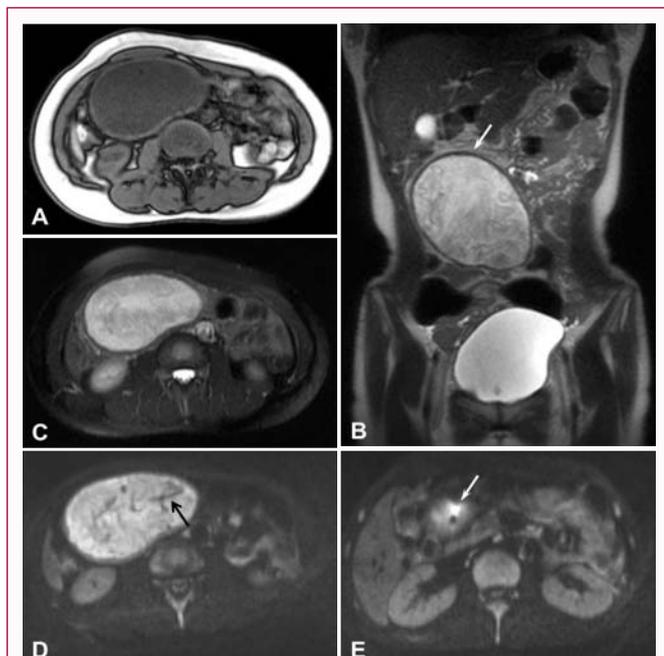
A 30-year-old woman with a mass in her abdomen 5 years after caesarean section. A-E: Unenhanced MRI scan showed a mass in her abdomen with complete capsule at the margin (white arrow), DWI showed swirling slightly lower signal shadow and strip lower signal band (black arrow) in the high signal background of the mass, and magnetic sensitivity artifacts (white arrow) can be seen locally.
